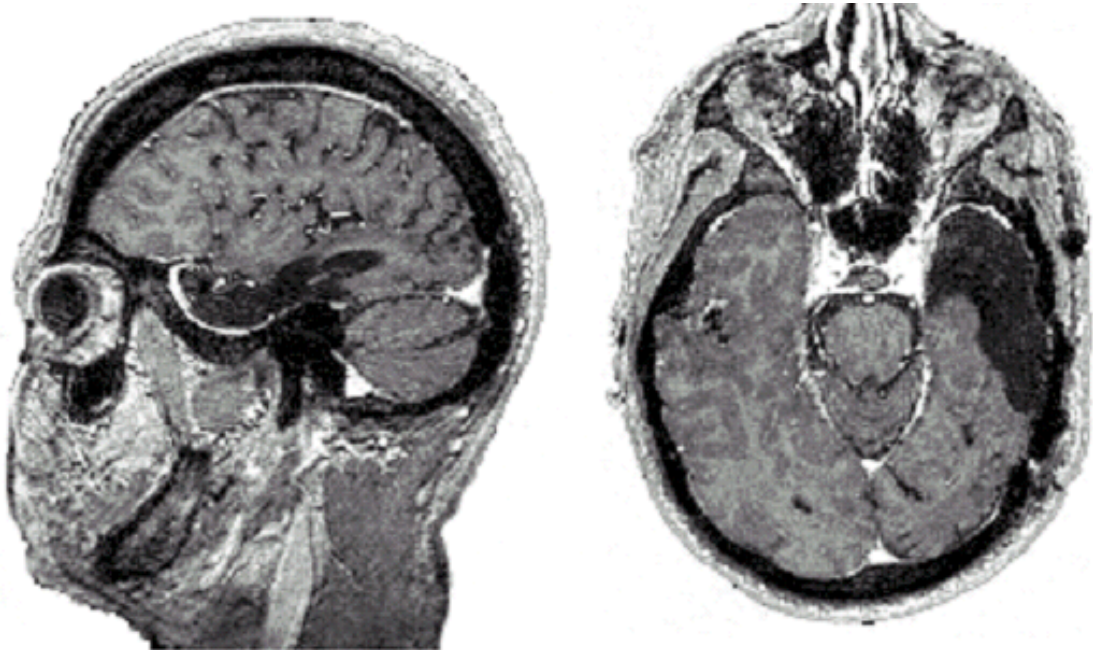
Sagittal (left) and transverse (right) views of a temporal brain resection seen with T1-weighted MRI.
